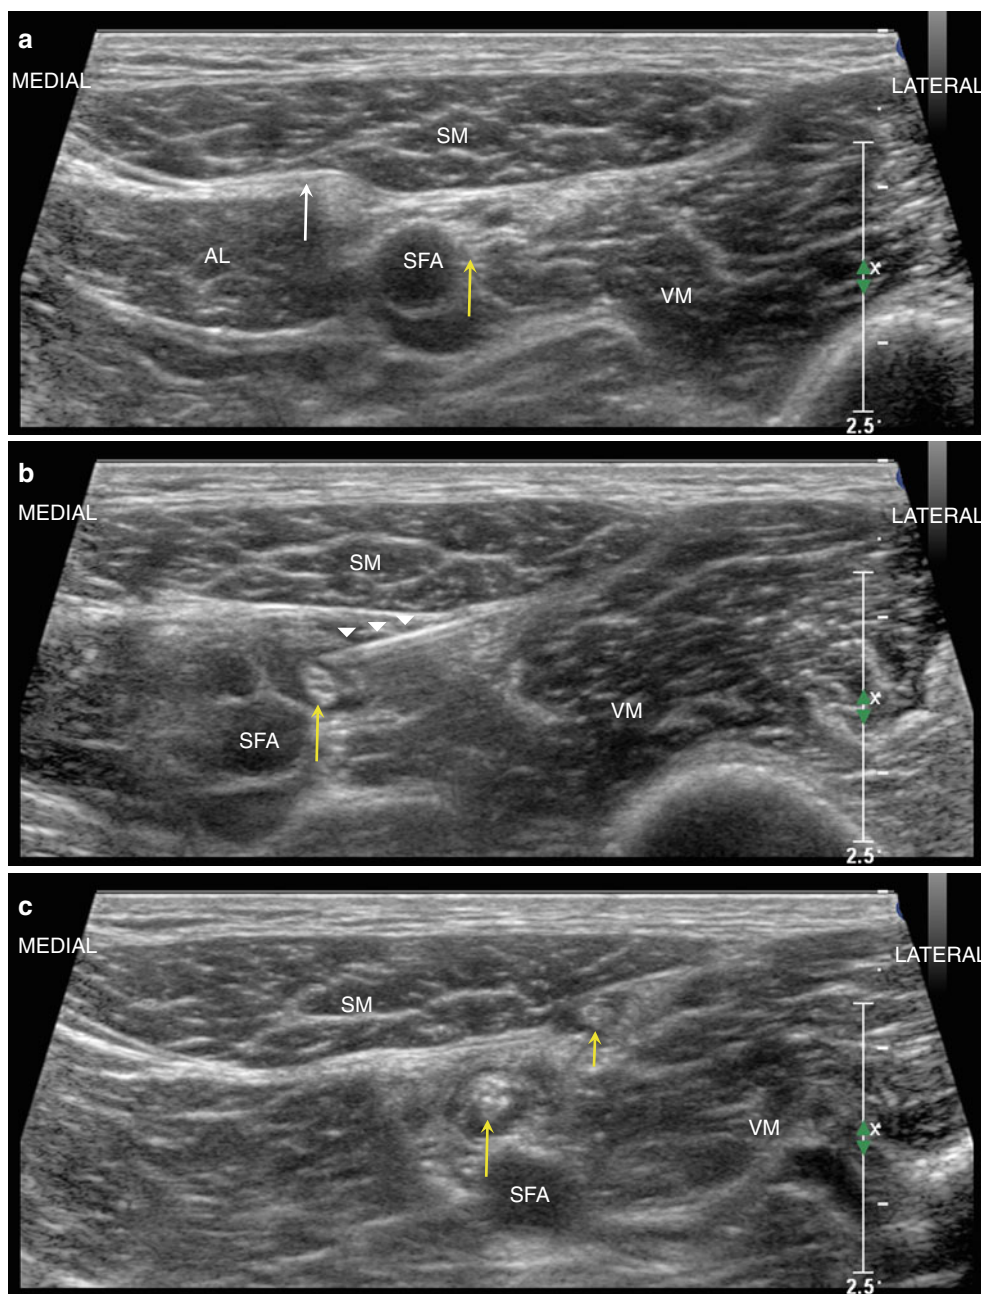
Serial sonograms demonstrating adductor canal block. Panel (a) baseline sonogram prior to injection (pre-scan). The saphenous nerve (long yellow arrow) lies deep to the sartorius muscle (SM) and hyperechoic vastoadductor membrane (white arrow) and is adjacent to the superficial femoral artery (SFA); adductor longus muscle (AL). Panel (b) in-plane approach to adductor canal block (the needle is shown with white arrowheads). Panel (c) distributions after injection tracked distally in the thigh demonstrating local anesthetic surrounding the saphenous (long yellow arrow) and infrapatellar (short yellow arrow) nerves. VM vastus medialis
